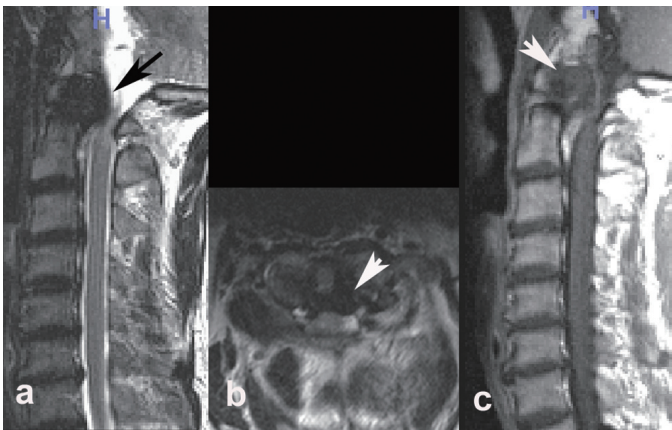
Preoperative T2-weighted MRI (a: sagittal image, b: axial image) showing the retroodontoid pseudotumor compressing the spinal cord. c: Preoperative MRI (T1-weighted after administration of gadolinium) showing no enhancement.
